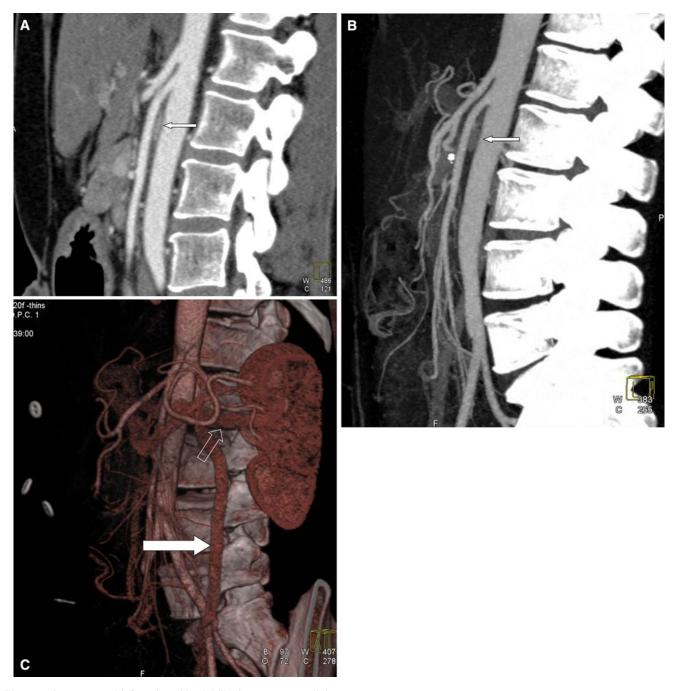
A 46-year-old female with debilitating post-prandial abdominal pain, which had led to severe weight loss. Sagittal contrast-enhanced (A) and sagittal maximum intensity projection (MIP) (B) CT images demonstrate severe narrowing of the aortomesenteric angle, with an aortomesenteric distance of only
